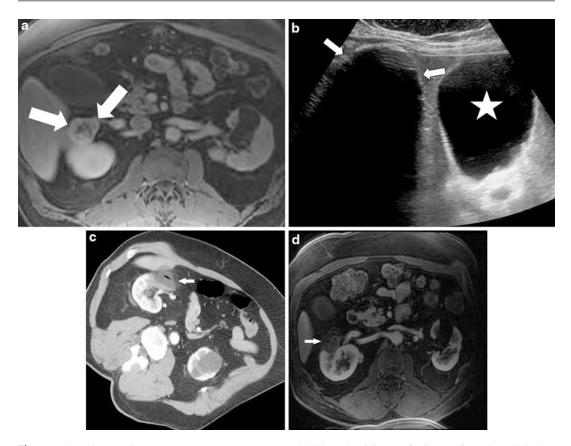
Anterior renal tumor. T1 post-contrast MRI image demonstrates a peripherally enhancing anterior renal mass (*arrows*) (a). Ultrasound image obtained during ablation demonstrates the echogenic ice ball (*arrows*) adjacent to the gallbladder (*star*) (b). Probe retraction
